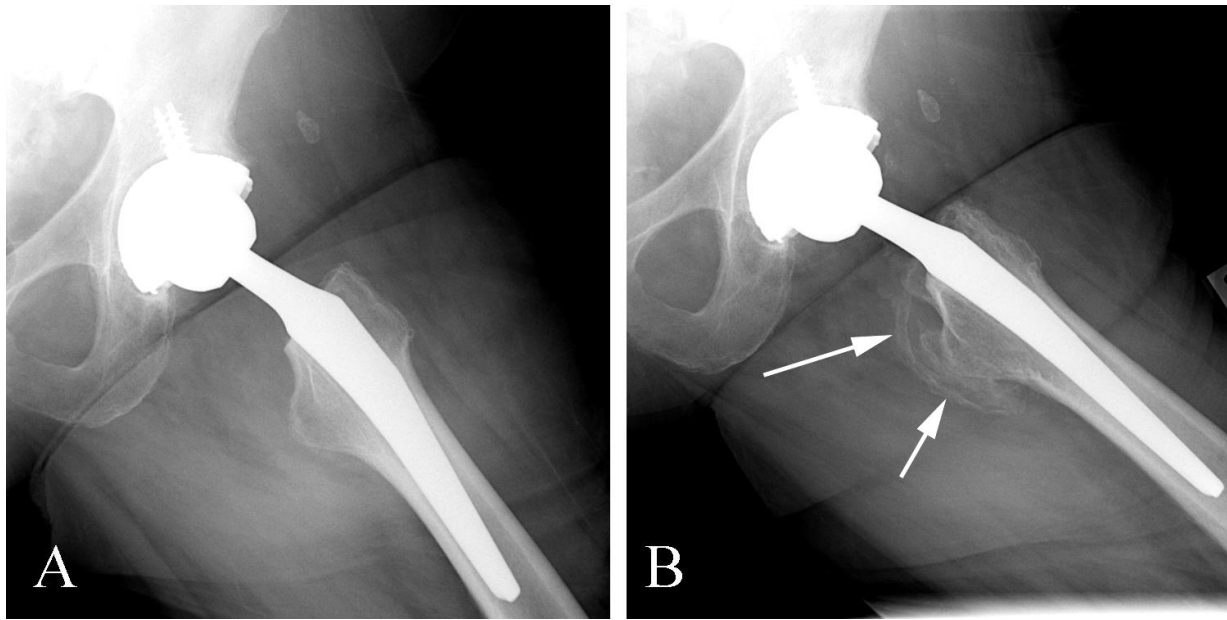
Dystrophic ossification in a 72 year old woman following hip prosthesis placement. A. Frog-lateral plain film of the hip following hip prosthesis placement demonstrates a normal post-operative appearance of the components and native bone and soft tissues. B. Frog-lateral plain film of the hip three months later demonstrates heterotopic bone formation along the hip joint margin (arrows).
